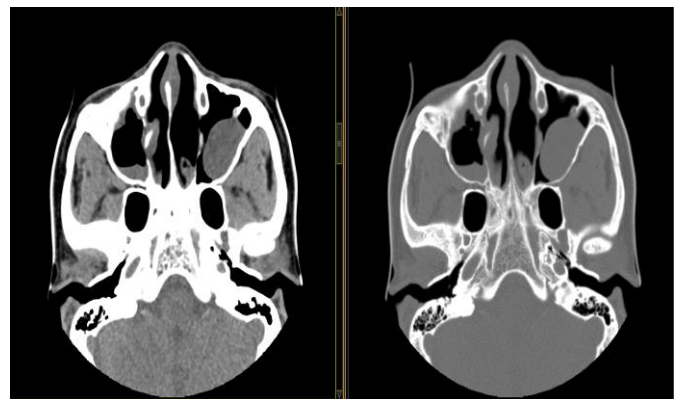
Axial CT of the antra showing an oval isodense lesion in the left antrum with a convex superior margin with no bony erosion. Mucosal thickening of the right antrum is also noted.
